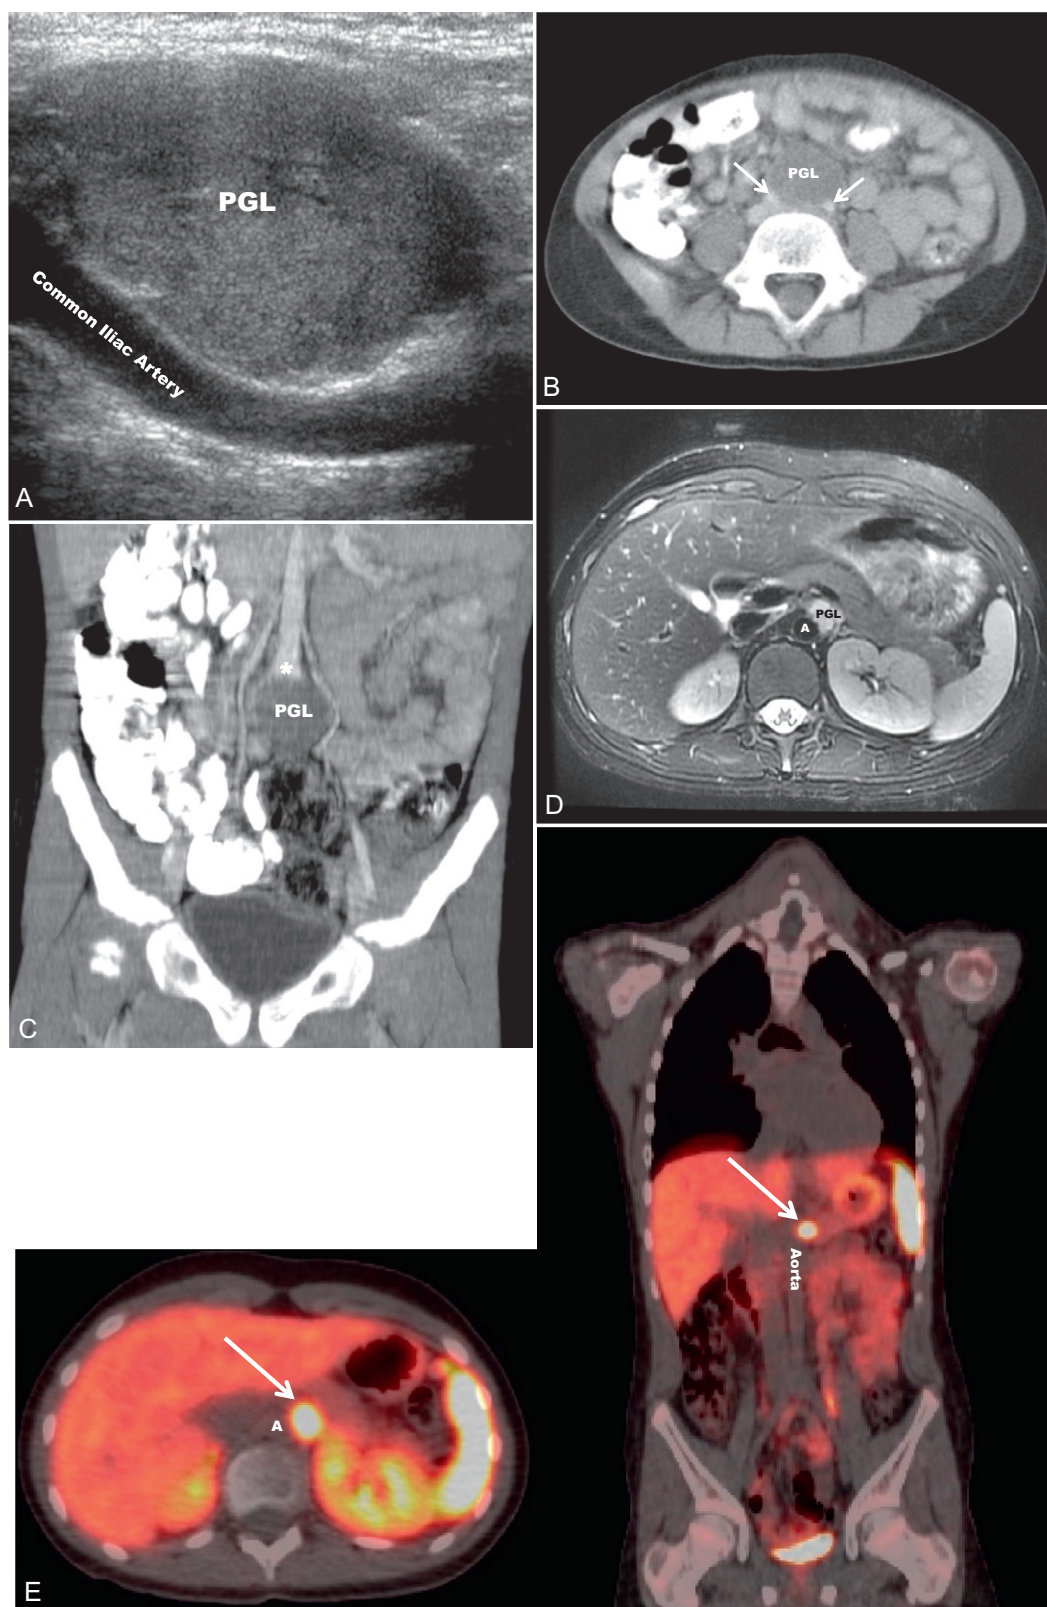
A 6-year-old female with a paraganglioma (PGL) and an *SDHB* mutation presented with severe hypertension during a well-child examination. A, Abdominal ultrasound (sagittal view) revealed a homogeneous, hypervascular 3.3-cm mass next to the common iliac arteries. Axial computed tomography (CT) postcontrast (B) (arrows, common iliac arteries) with coronal reconstruction (C) confirmed a tumor at the aortic bifurcation (asterisk). A 13-year-old boy with an *SDHB* mutation developed elevated blood pressures and abnormal norepinephrine, normetanephrine, and chromogranin A levels during prospective screening. T2-weighted axial images from abdominal magnetic resonance imaging (D) revealed a 2-cm paraaortic mass (PGL) between the origins of the celiac axis and superior mesenteric artery that was T2 hyperintense. This was subsequently confirmed via functional imaging with ^{68}Ga -DOTATATE positron emission tomography/CT (E) to be a paraganglioma (arrows). A, Aorta.
